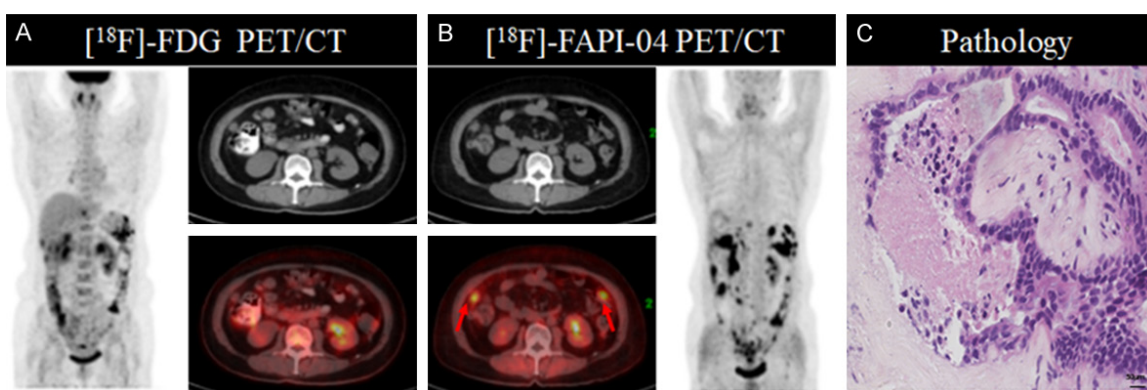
Detection results of abdominal metastatic tumor. A 64-year-old woman was admitted with a 2-month history of abdominal distention. Abdominal ultrasound revealed a predominant abdominal mass, which was suspected to be malignant. Further evaluation with [¹⁸F]-FDG PET/CT and [¹⁸F]-FAPI-04 PET/CT was performed before treatment. A. FDG: No abnormal radioactive distribution is seen. B. FAPI: Nodular shadow is seen in bilateral paracolic sulcus, SUVmax: 5.9. C. Surgical pathology shows intra-retinal adenocarcinoma, Scale bar, 50 μm.
